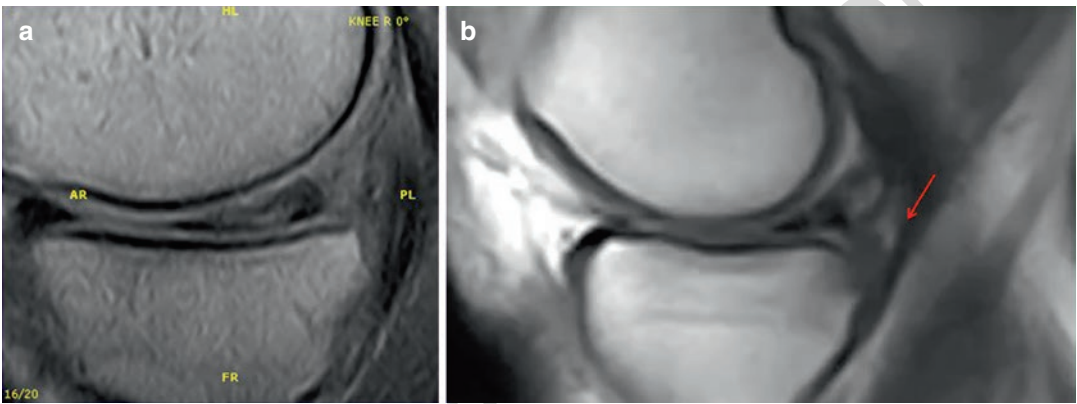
(a, b) Chronic rupture of the meniscal body and of the posterior horn of the medial meniscus. Whereas the static MRI scan suggests that the lesion is stable, the dynamic scan documents clear meniscocapsular instability
